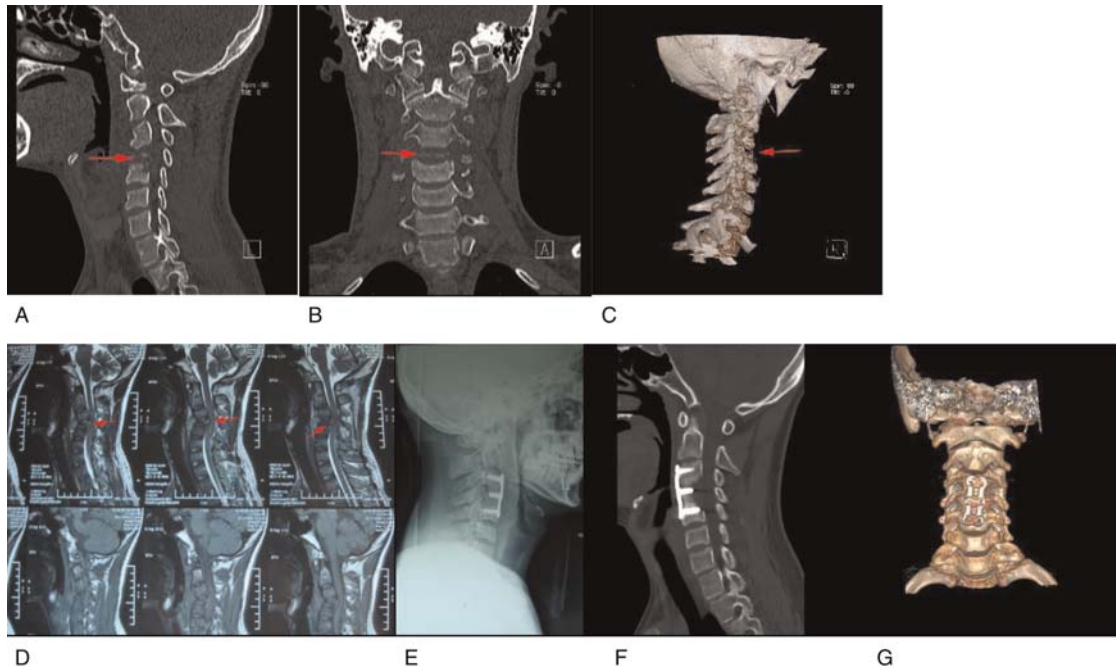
(A–C) CT scan view showing osteolytic destruction of the C4 vertebrae. (D) MRI scan view showing osteolytic destruction of the C4 vertebrae, formation of paravertebral and intraspinal abscess. (E–G) Postoperative imaging study showing that the lesion has been completely removed and that the position of the internal fixation device is satisfactory. Postoperative bone bridge formation is visible in the diseased vertebral body. CT = computed tomography, MRI = magnetic resonance imaging.
